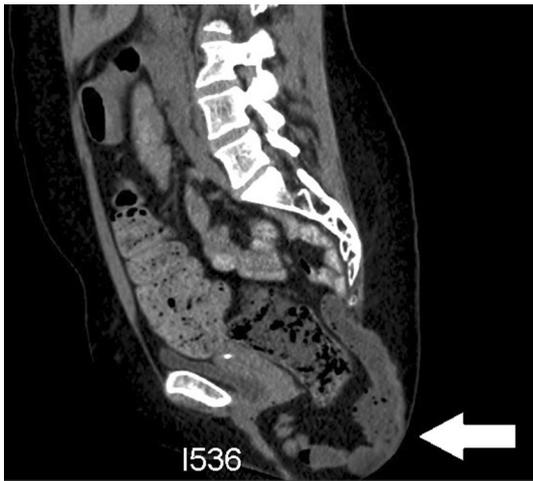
Sagittal CT view of the hernia (arrow)
